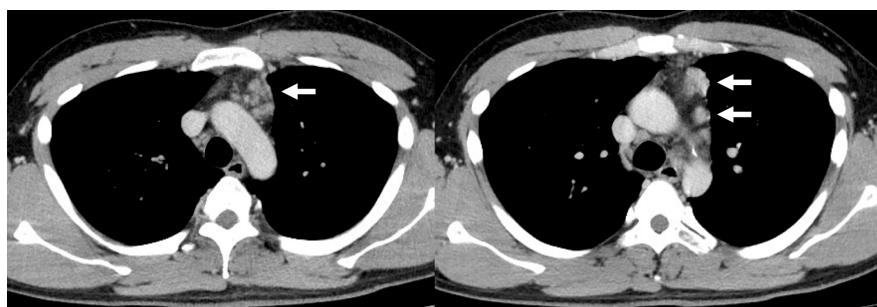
The chest computed tomography (CT) scan showing an anterior mediastinal lesion (arrow).
